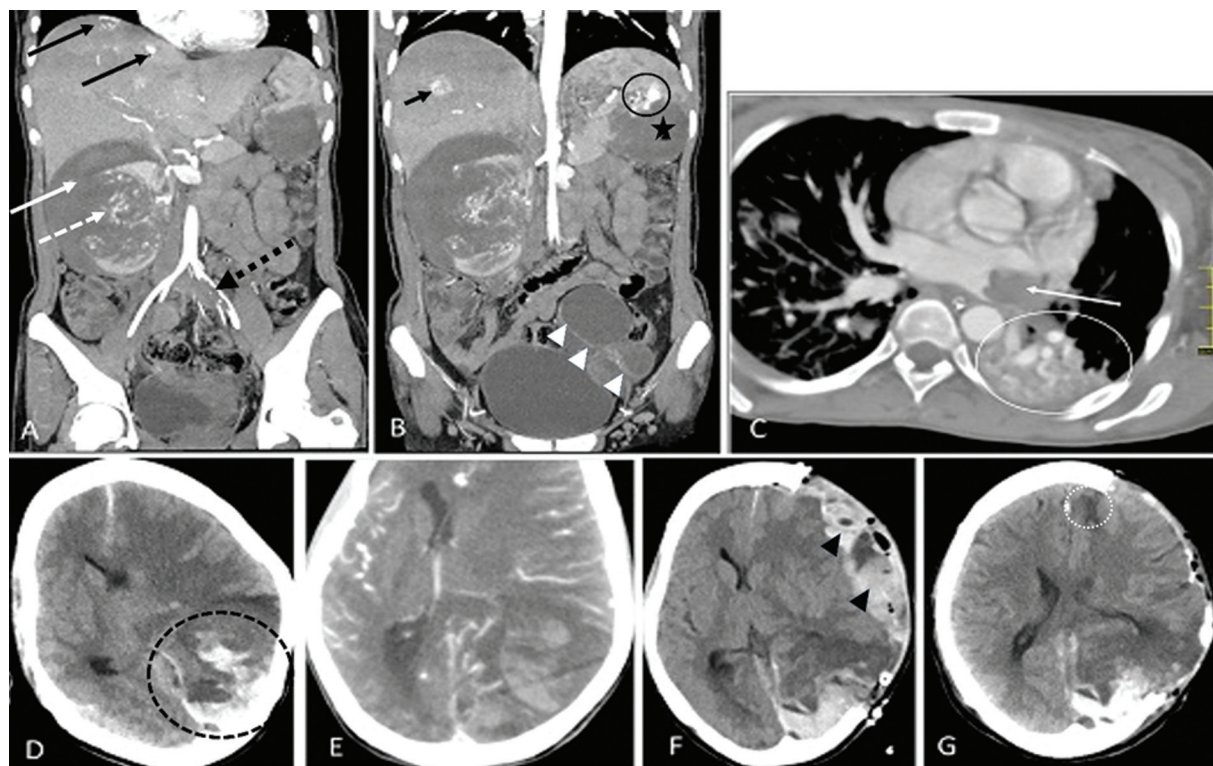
Computed tomography (CT) panel. (A) Coronal image showing multiple nodular and peripherally enhancing lesions in liver (black arrows), and the right kidney is almost completely replaced by a heterogeneous nodular enhancing mass (dashed white arrow) with perinephric hematoma (solid white arrow), the lesion having been ruptured and the lateral margin of kidney not visualized, a filling defect is seen in the left common iliac artery due to thrombus (dashed black arrow). (B) Coronal image showing a peripherally enhancing liver lesion (short black arrow) and nodule enhancing lesion in spleen (black circle) with a hematoma (black star), white arrowhead points to a complex, predominantly cystic lesion in the pelvis. (C) Axial image of the chest showing a hypodense thrombus in the left atrium (white arrow) and a bunch of enlarged tortuous vessels within an area of consolidation in the superior segment of the left lower lobe (white oval). (D) Head CT on the day of renal embolization, showing left parieto-occipital lobe hematoma (dashed black circle) with mass effect and midline shift to the right. (E) Axial source image of a CT angiography of the head showing no abnormal vessels in or around the hematoma. (F) Axial head CT image immediately after first surgery showing residual parieto-occipital hematoma, a large extradural hematoma in the left frontoparietal region (black arrowheads). (G) Axial CT head image after second surgery showing fresh heterogeneous area suggestive of hemorrhage in the left frontal lobe anteriorly (dashed white circle), the extradural hematoma, and midline shift has significantly resolved. Patient died few days later, however.
